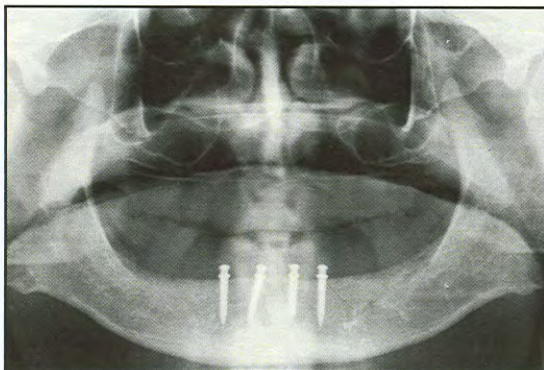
Postoperative panoramic radiograph of four NDIs placed between the foramina.
